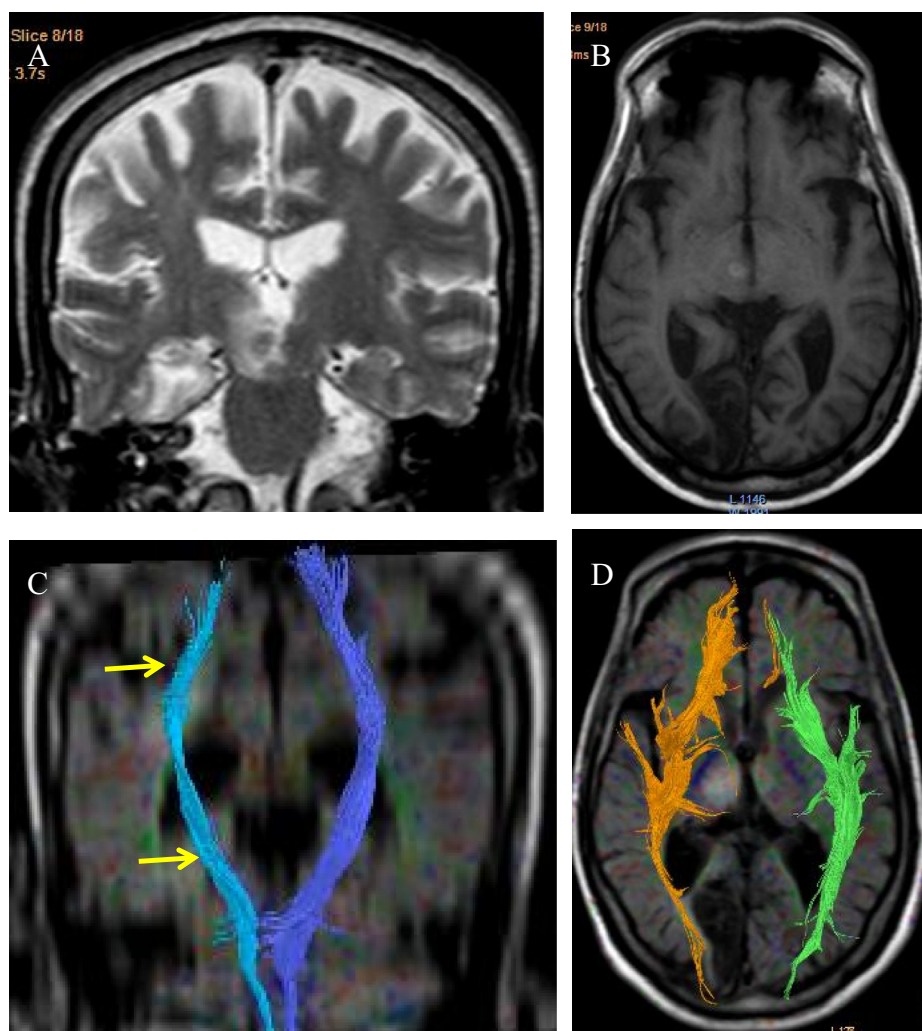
67 years old female patient with history of old stroke presented with left sided weakness. (A) Coronal T2 WIs shows small right thalamic and right cerebral peduncle infarction measuring about 1.5×1.2 cm in diameters. (B) Axial T1 WIs shows small hemorrhagic component of the right thalamus and right occipital encephalomalacia. (C) Coronal FA color coded map overlaid over coronal FLAIR image with fiber tractography of the CSTs showing reduced caliber of the right CST throughout its course (arrows). (D) Axial FA color coded map overlaid over axial FLAIR image with fiber tractography of the IFO fasciculi showing reduced caliber of the posterior part of the right IFOF (orange).
